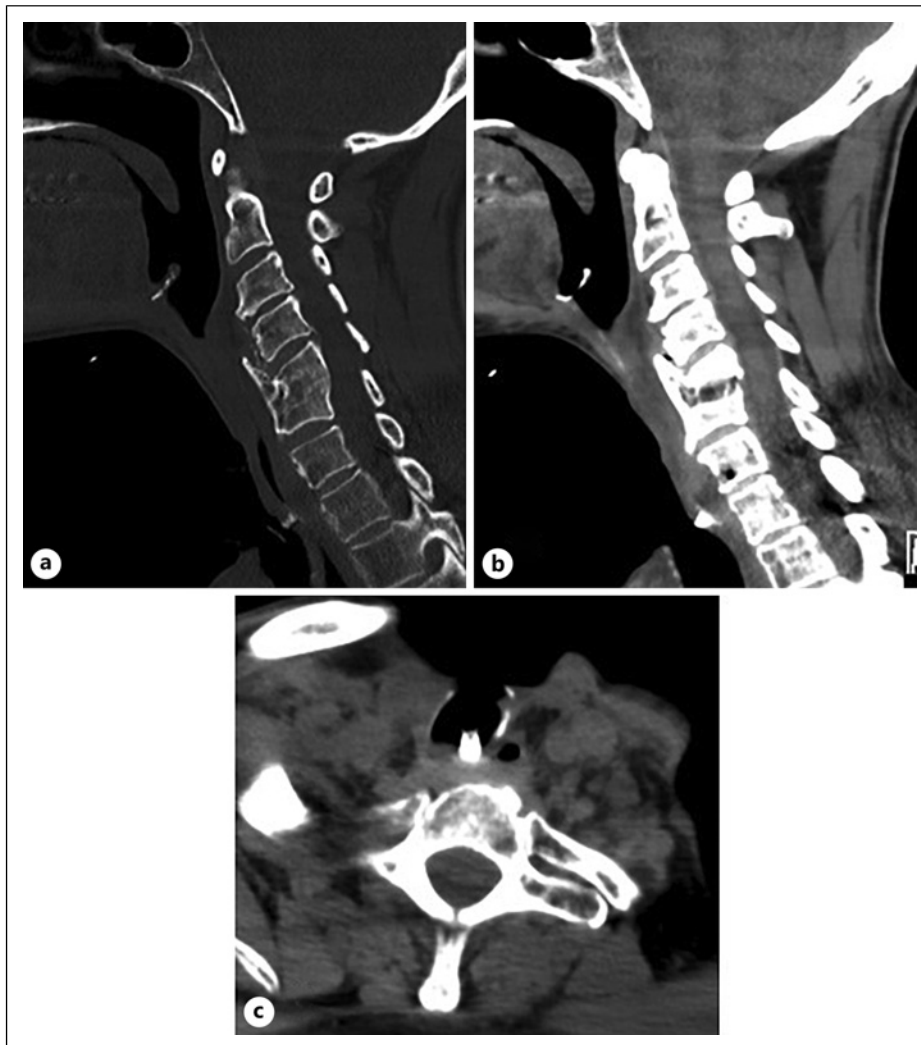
CT of the cervical spine performed on May 13, 2022; reconstructions in the sagittal plan in bone (a) and soft tissue (b) windows; and axial section in soft tissue window (c) show the usual post-surgical changes of total laryngectomy with a phonatory prosthesis in normal position. Also noteworthy is the presence of a C5–C6 vertebral block and small posterior protrusions of the C4–C5 and C6–C7 discs.
